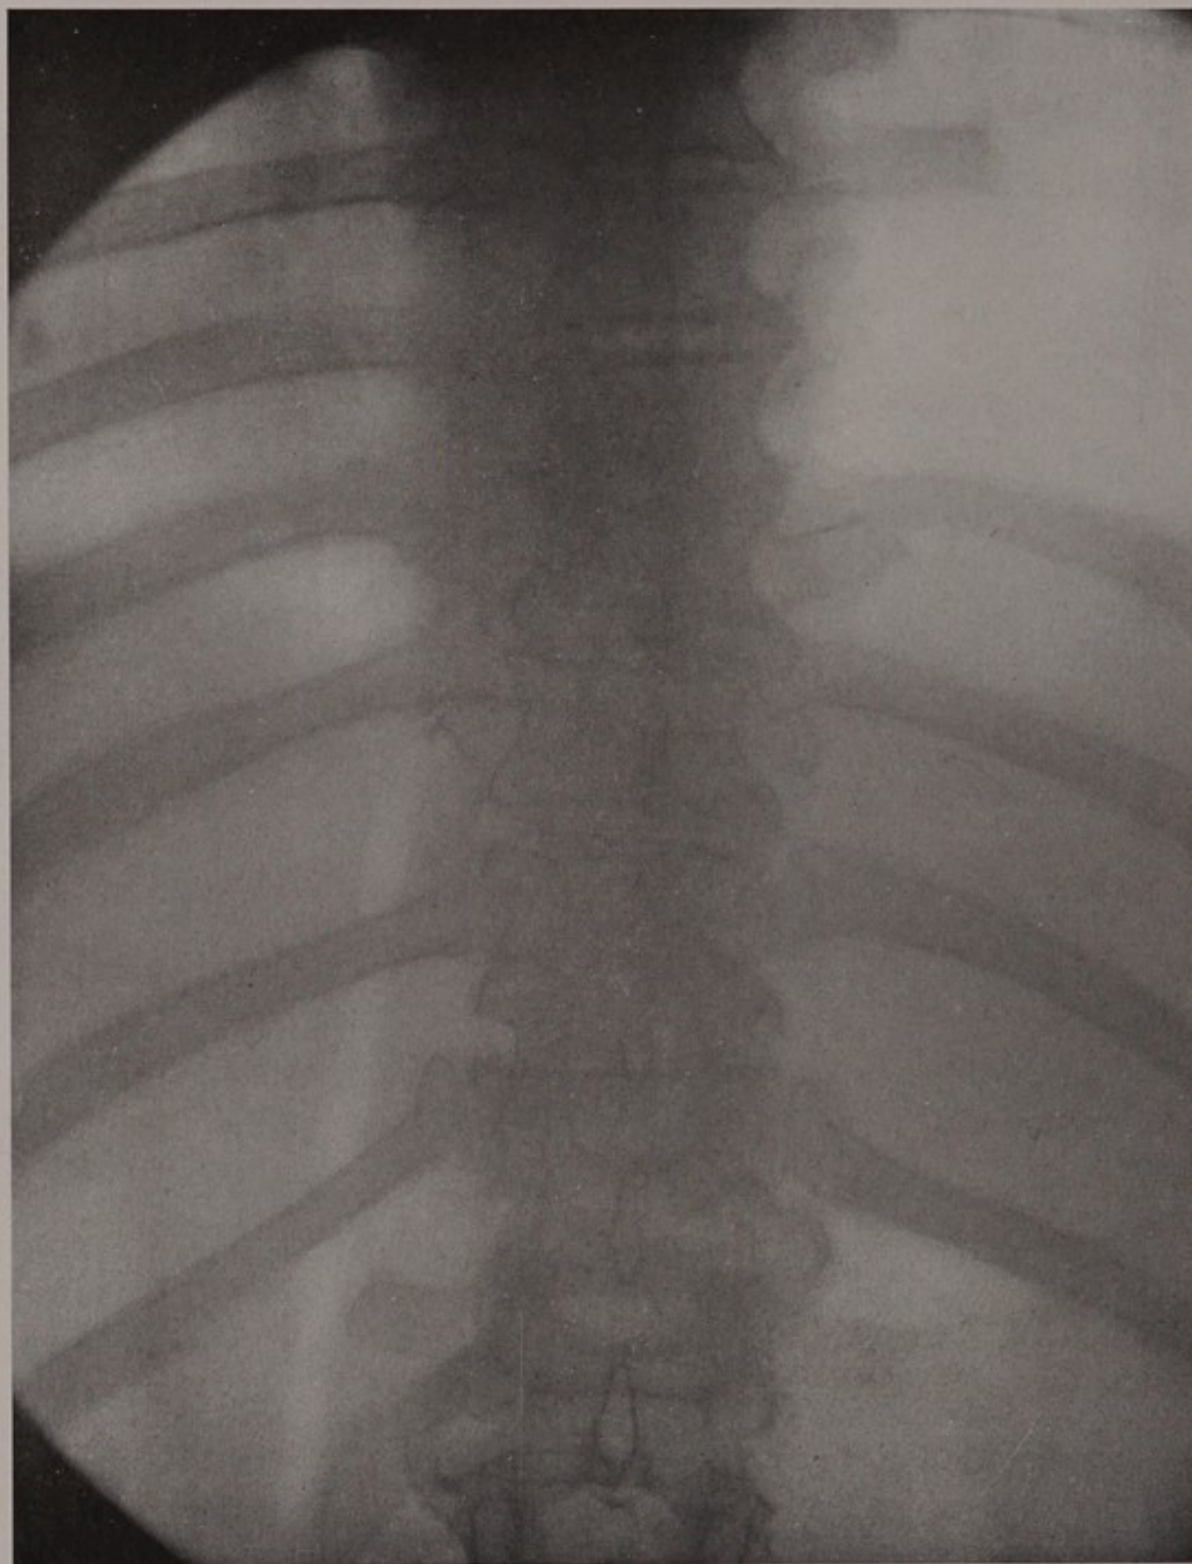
Spondylitis of the dorsal and lumbar vertebræ. This X-ray appearance is often presented by patients with a spinal tumor.
